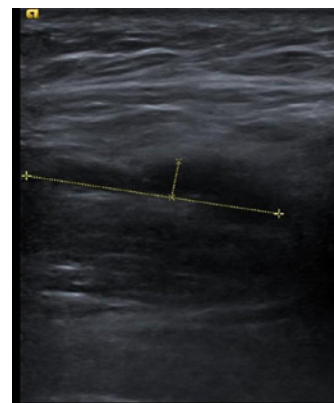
Ultrasound image of collection in the left hip.
